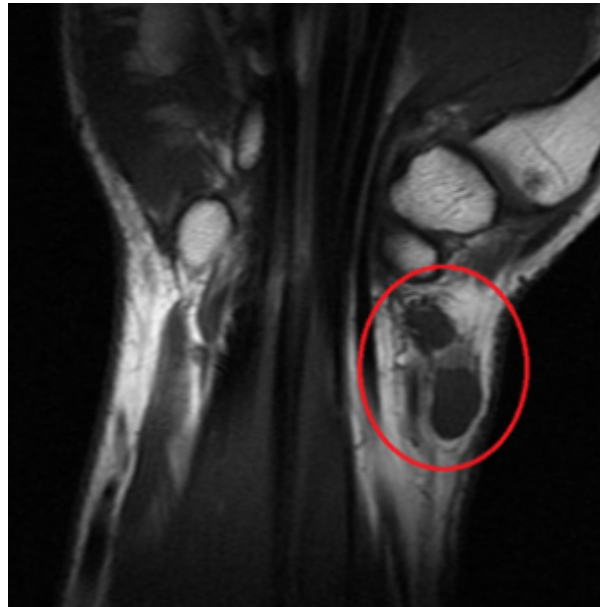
MRI of volar wrist ganglion
